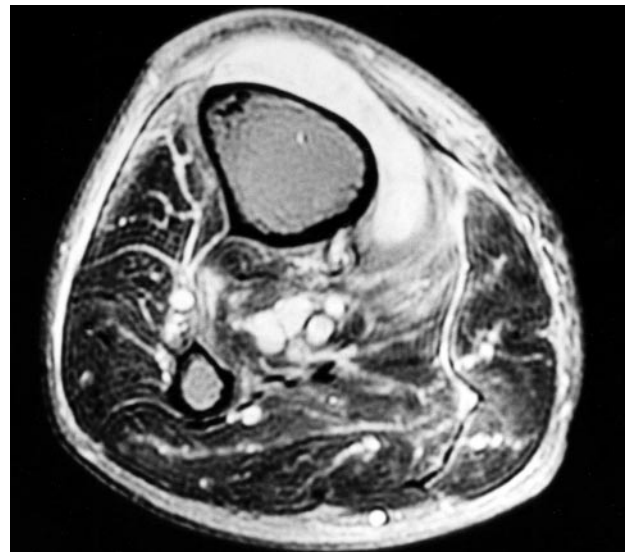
An axial T2 weighted fat suppression MRI scan shows the hyperintense pretibial mass. Diffuse, inhomogeneous hyperintensity is observed in the subcutis and the gastrocnemius and soleus muscles, suggesting inflammatory changes.
